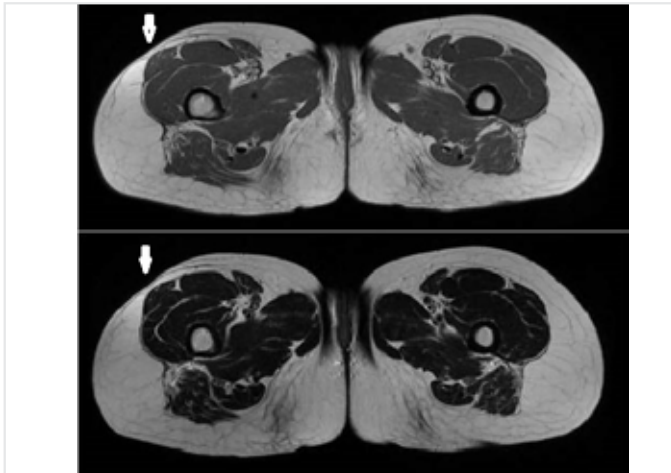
Lower extremity magnetic resonance imaging, axial T2 weighted sequences showed localized atrophy in adipose tissue on the anterolateral part of right thigh
